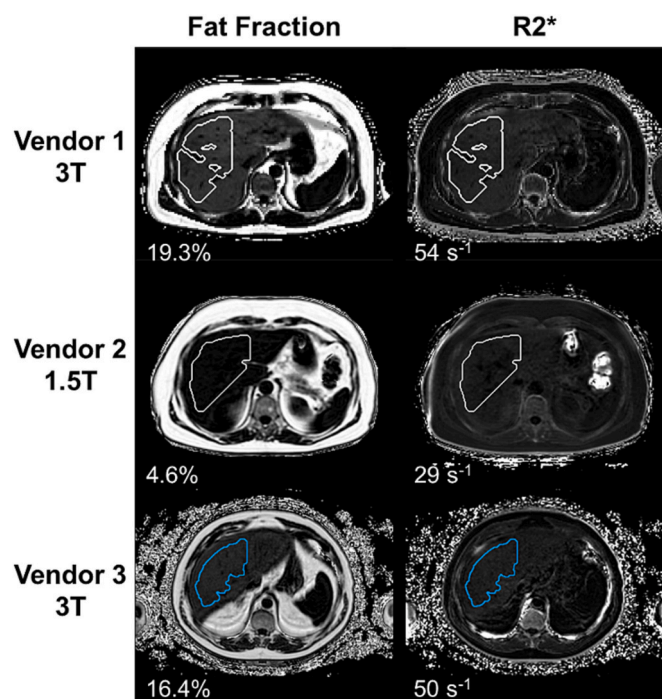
Sample data analysed by the Resoundant core lab. Vendor-specific PDFFF (vPDFFF) sample images from 3 different subjects and MRI scanner manufacturers. Fat fraction images (left column) and R2* images (right column) with applied ROIs and corresponding mean values are shown.
